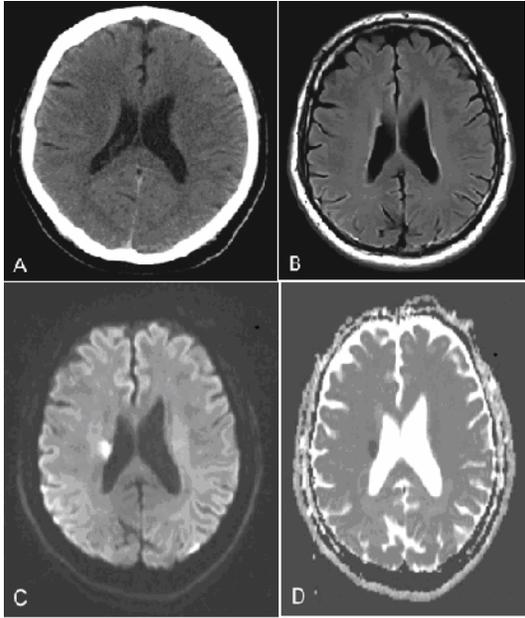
(A–D): 62 year old man with hypertension admitted 1.5 hour after the onset of left sided hemiplegia. CT (A) was normal. The patient treated with tPA with no significant improvement of hemiplegia. MRI performed 4.5 hours after ictus showed no abnormality on FLAIR (B), increased signal intensity on DWI in the corticospinal tract at the level of corona radiata (C), and markedly decreased ADC-value (D) of the same region suggestive of acute lacunar infarction.
